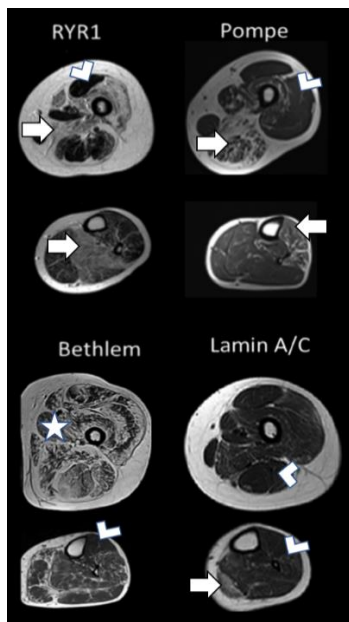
Muscle MRI for clinically similar muscular dystrophies differentiates patterns of muscle involvement.
